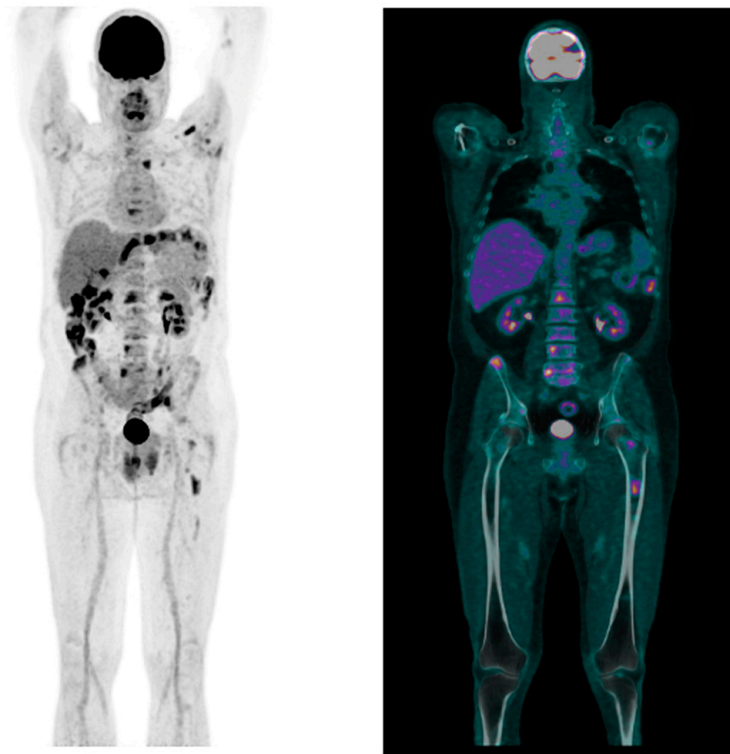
18-FDG PET/CT showing the presence of high-metabolism lesions in the left clavicle, ipsilateral humeral head, right scapula, bilateral iliac bones, left femoral diaphysis, and multiple vertebral segments.
